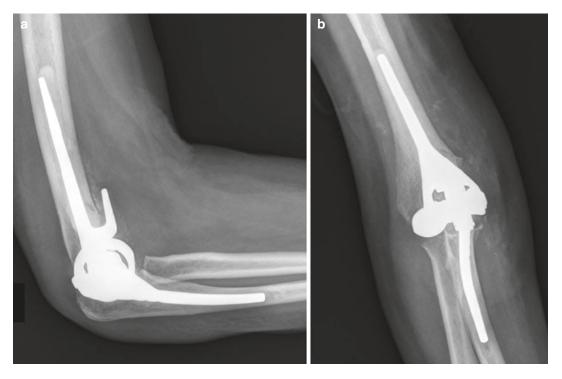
X-rays obtained at 1-month follow-up: (a) lateral view and (b) anteroposterior view from total elbow arthroplasty with a Latitude convertible implant
